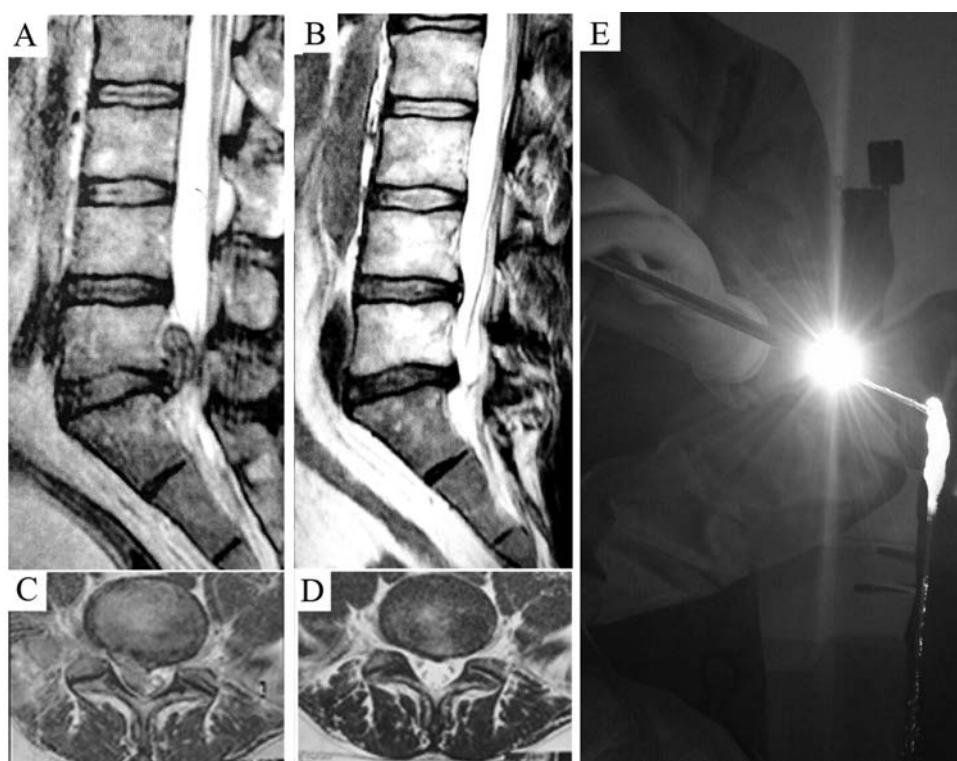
Magnetic resonance images of the lumbar spine during the preoperative period in (A) sagittal section and in (B) axial section, and in the postoperative period in (C) sagittal section and in (D) axial section. Note the presence of a bulky fragment in the preoperative images, which was removed during the surgery (E), and the resulting decompression of the vertebral canal and the maintenance of bone and muscular integrity in the postoperative images.
